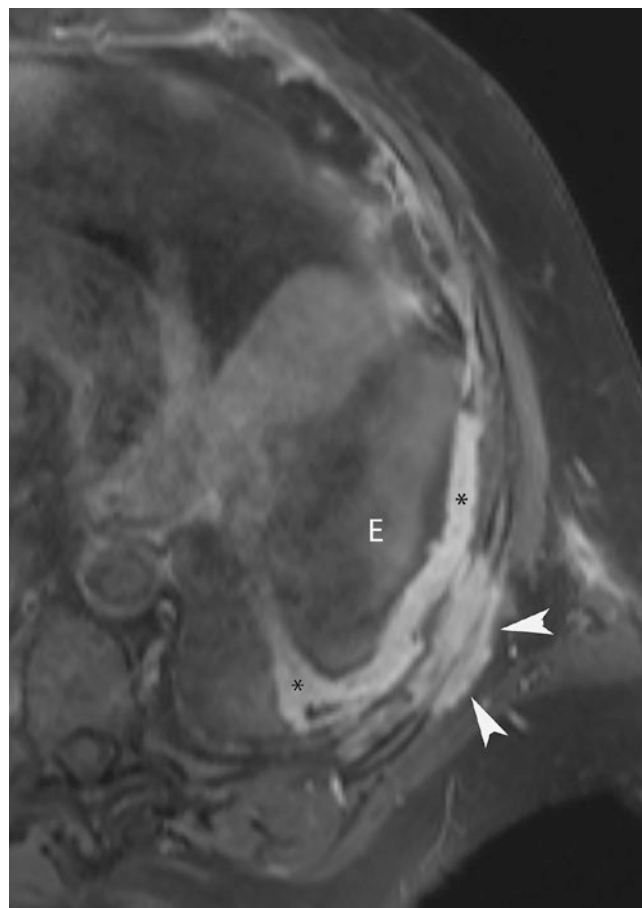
Contrast-enhanced axial T1 fat saturation MRI image with nodular enhancing pleural thickening (*) and a malignant pleural effusion (E). Areas of abnormal enhancing soft tissue extend into the chest wall (arrowheads) consistent with chest wall invasion of malignant pleural mesothelioma. MRI is superior to CT in the evaluation of chest wall invasion
